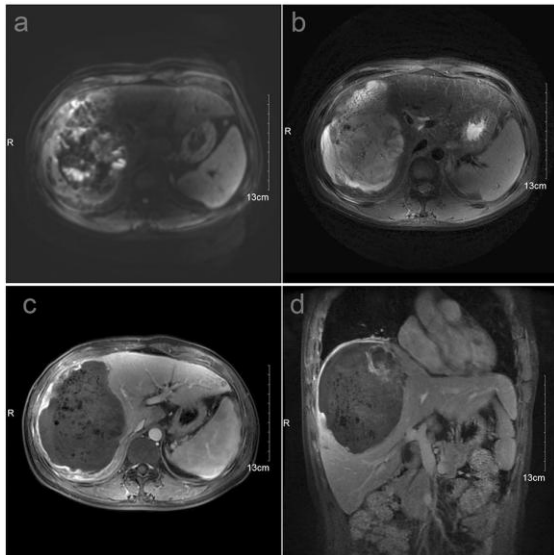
Patient B treated with TILA-TACE. The outcome of the first session of treatment. Twenty days after treatment, the patient was scanned with MRI, which demonstrated a near complete necrosis of the tumor. (a) DWI. (b) T2WI. (c) Axial, T1WI with contrast-enhanced MRI, arterial phase. (d) Coronal, T1WI with contrast-enhanced MRI, arterial phase.
